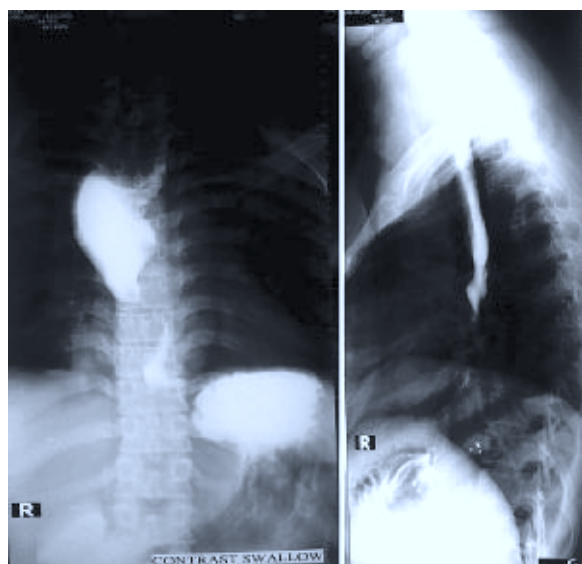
Barium swallow X-ray of esophagus showing narrowing in the midpart of esophagus with proximal dilatation with normal mucosal patterns.
